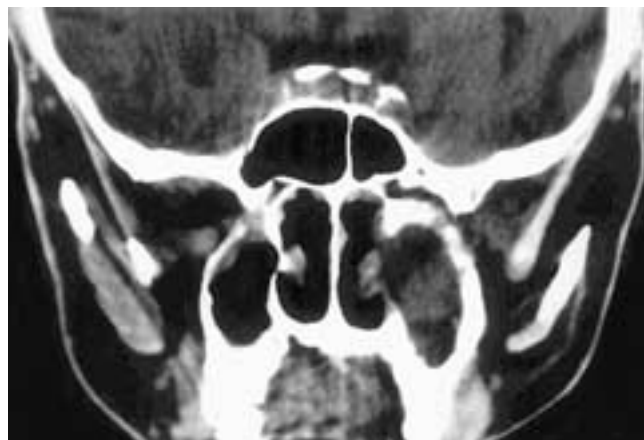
Coronal CT scan shows mucosal thickening in the left maxillary sinus associated with thickened, sclerotic bone in the sinus walls. However, unlike Figures 5-23 and 5-24, there are areas of rarefaction and early sequestrum formation along the upper antral wall. Minimal mucosal disease is also present in the right maxillary sinus. This patient had chronic sinusitis with osteomyelitis.
